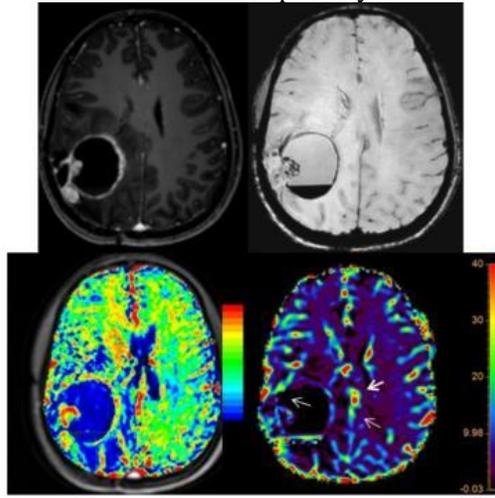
Patient with recurrent tumor with foci of susceptibility in the mural nodule as well as blood fluid level in the cystic component. The mural nodule is showing high CBV on T1- perfusion. Corresponding area shows relatively low CBV on T2* perfusion MRI. Another foci of increased CBV seen posteriorly detected well on both T2*- and T1- perfusion MRI. Artfactual increased CBV is seen within the cystic component of the tumor on T2*- perfusion.
